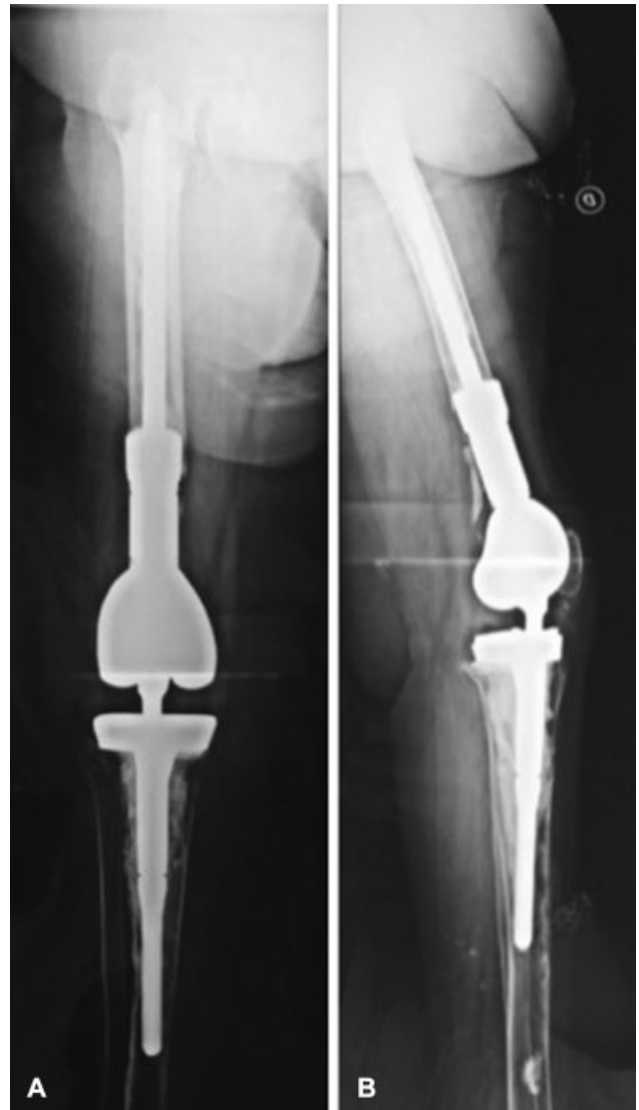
Anteroposterior (A) and lateral (B) X-rays show good positioning of the Zimmer Segmental System at the 5-year follow-up.
